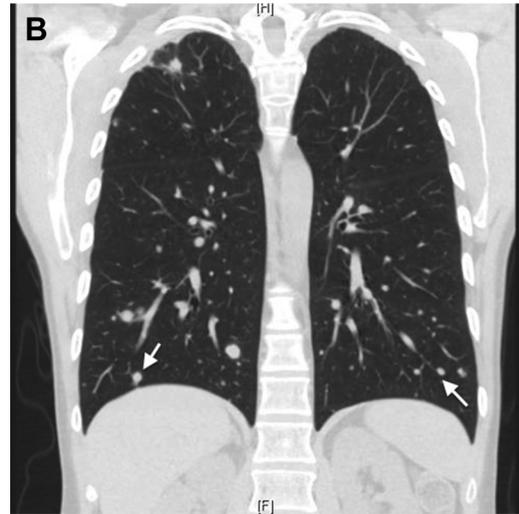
A, CT scan of the chest revealed innumerable solid nodules concentrated at the periphery and the bases in a perivascular distribution. B, In the coronal view, feeding vessels (arrows) can clearly be seen at both the right and left lung bases.
